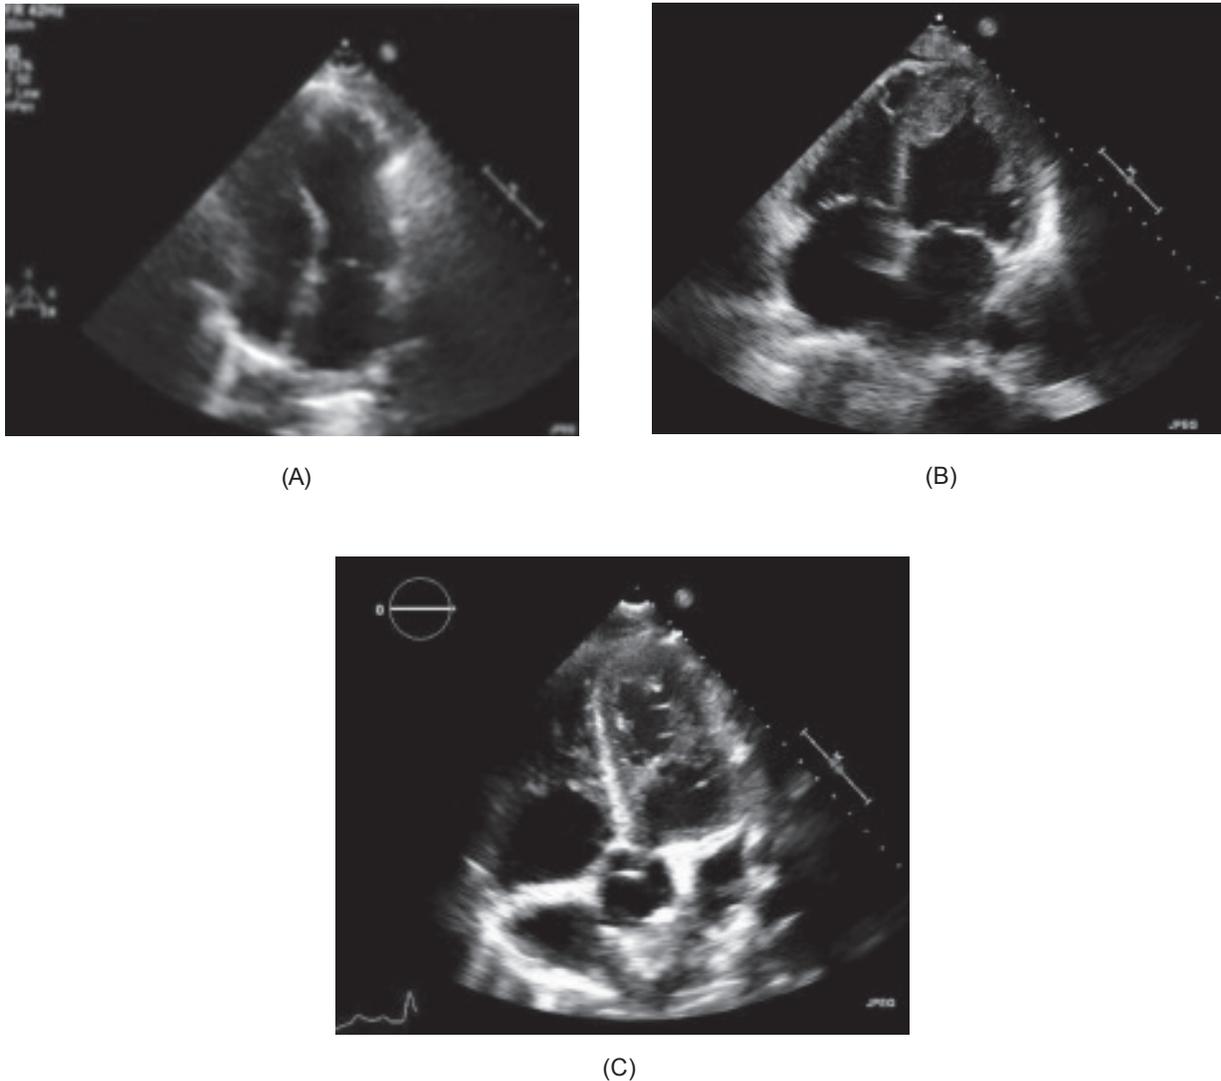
A) Representative 2D transthoracic echocardiogram images of Takotsubo Cardiomyopathy B) Patient with left ventricle(LV) thrombus, C) LV non compaction
